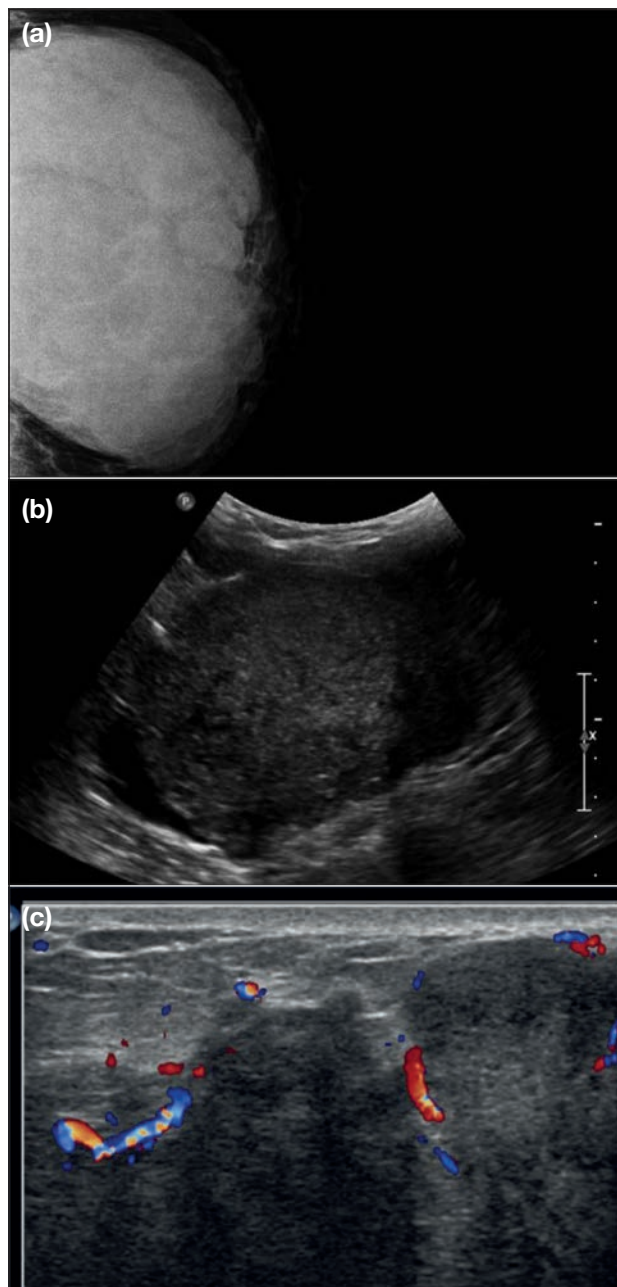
Borderline phyllodes tumour of left breast in a 63-year-old woman with a palpable lump. (a) Left mammogram showing an oval circumscribed hyperdense mass. (b, c) Ultrasonograms showing an oval circumscribed complex echoic mass with increased internal vascularity.
